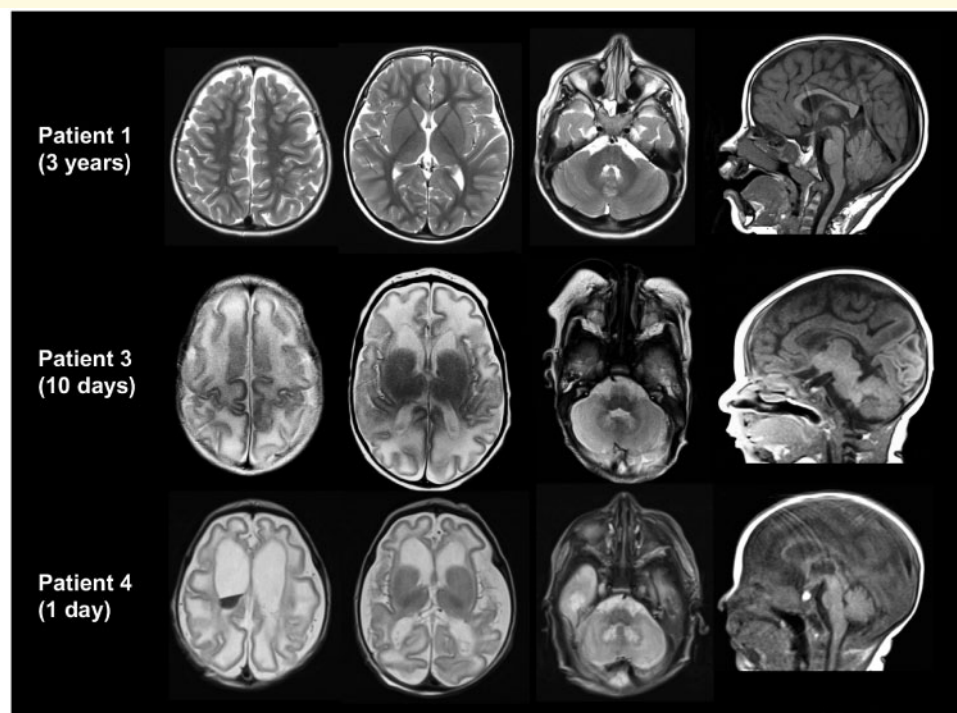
Axial T₂ (first three columns) and sagittal (last column) T₁-weighted images of Patients 1, 3 and 4. At age 3 years, the MRI of Patient 1 is normal. Patients 3 and 4 show a simplified gyral pattern, cyst-like structures connected to the anterior horns and a T₂-hyperintense signal of the hilus of the dentate nuclei. White matter signal is T₂ hyperintense and appears swollen. These abnormalities are more severe in Patient 4 (who additionally has intraventricular blood) than in Patient 3. The corpus callosum lacks the most posterior part.
